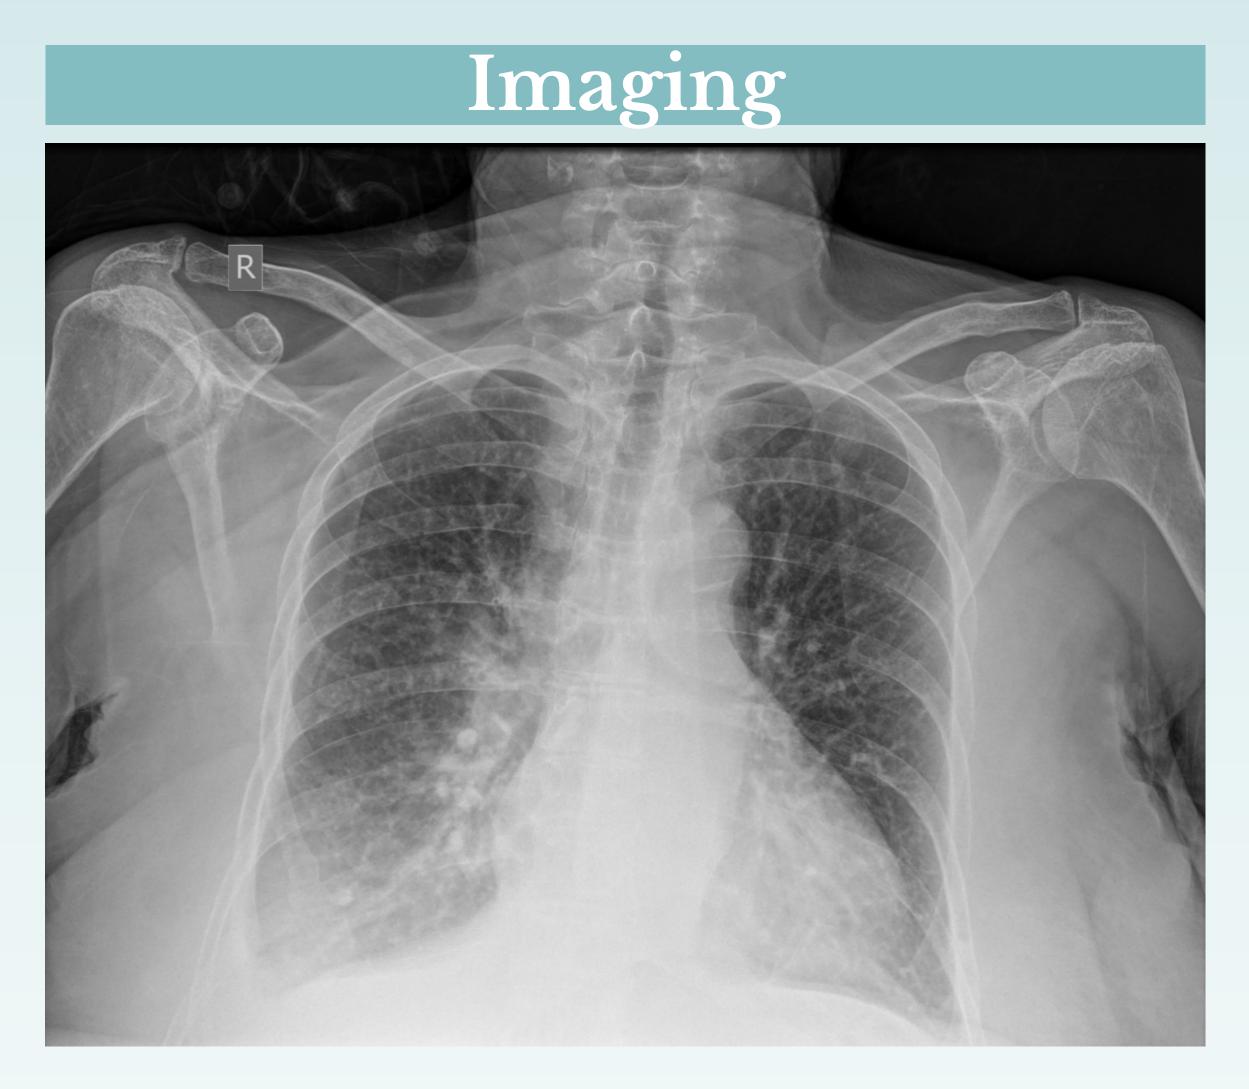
1-view Chest X-ray showing moderate pulmonary congestion, small bilateral pleural effusions, and an increased density in the right lower lung likely due to a layered pleural effusion
